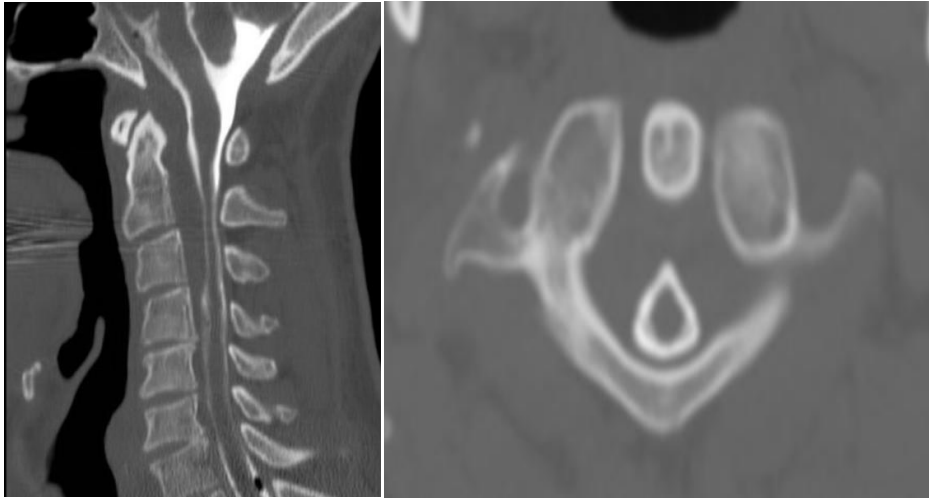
Preoperative CT myelogram of the cervical spine. On the left, a midsagittal image reveals the severe stenosis caused by the ventral venous engorgement. On the right, an axial view is seen confirming the severe stenosis.
